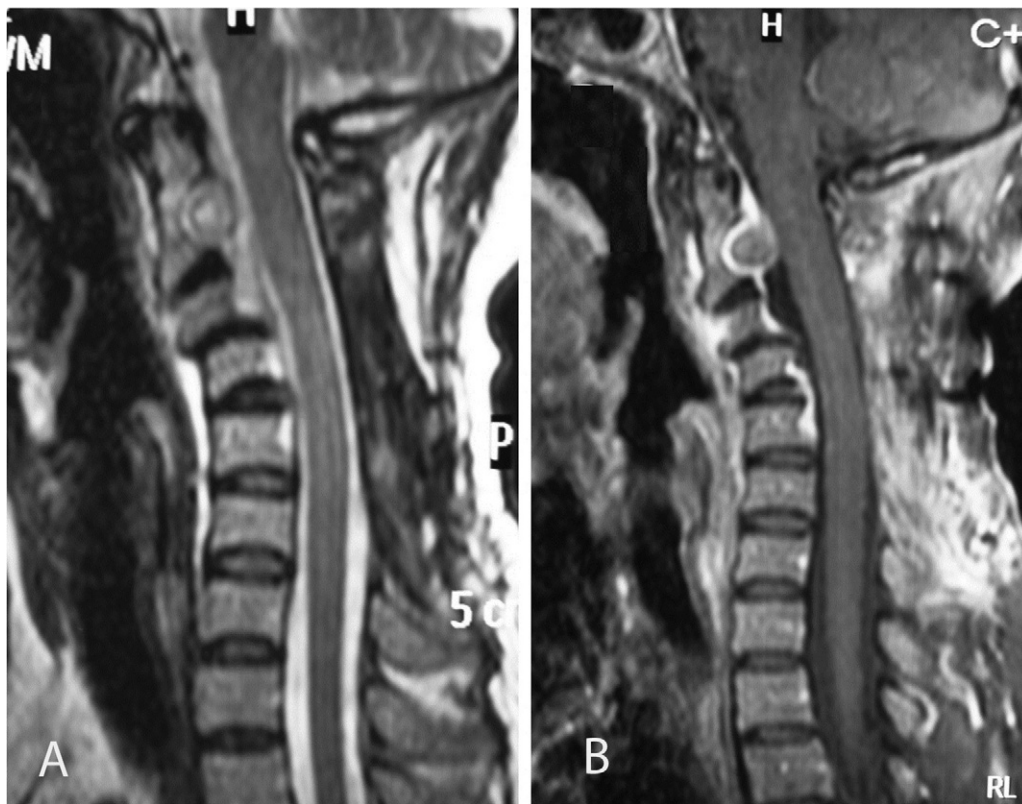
The postoperative sagittal T2-weighted (A) and T1-weighted (B) images with gadolinium demonstrate rapid resolution of the upper cervical mass within two months and minimal C3–4 dislocation.
